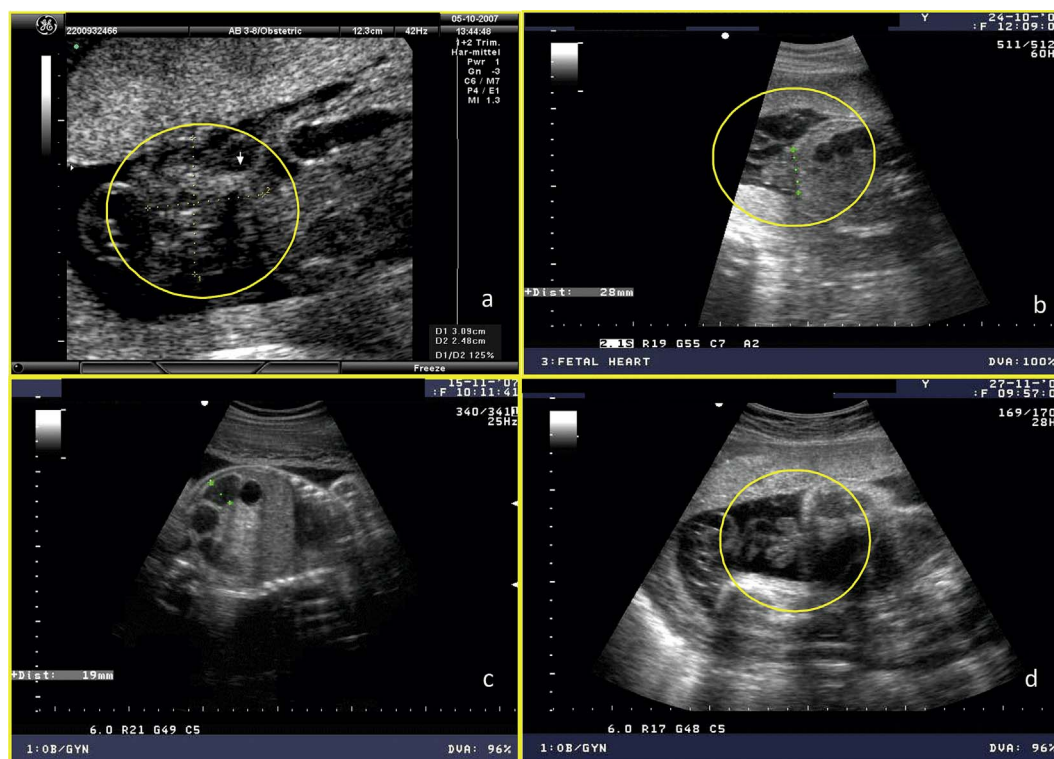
a. Ultrasound findings at 26 weeks of pregnancy with 28 x 20 mm intestinal convolute in front of the anterior abdominal wall with expanded intraabdominal intestinal loops according to Doppler sonography with good blood flow to the prolapsed intestine. b. Ultrasound findings performed in the 29th week of pregnancy with detectable intestinal convolute in front of the anterior abdominal wall (abdominal wall defect 28 mm in size), which widens the intraabdominal intestinal loops. c. Ultrasound findings at 32 weeks of pregnancy with detection of enlarged bowel loops in the abdomen. d. Ultrasound findings at 34 weeks of pregnancy (immediately prepartal): Intestinal convolution is located in front of the anterior abdominal wall, but the abdominal wall defect can not be shown with certainty.
